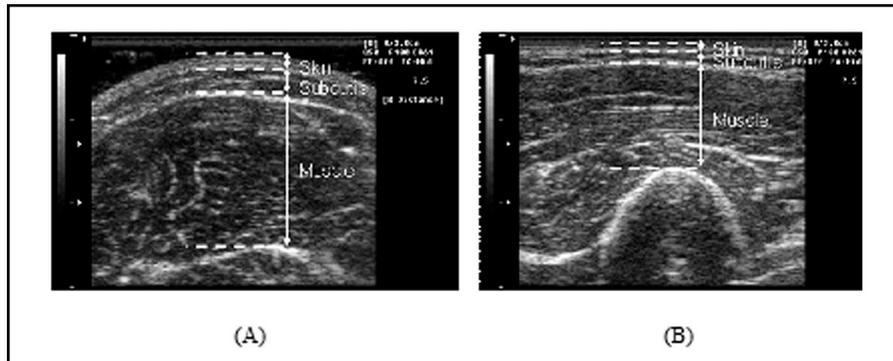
Ultrasound images of a patient with breast cancer-related lymphedema demonstrating imaging with negligible pressure (A) and with control of precise 2N pressure (B).
